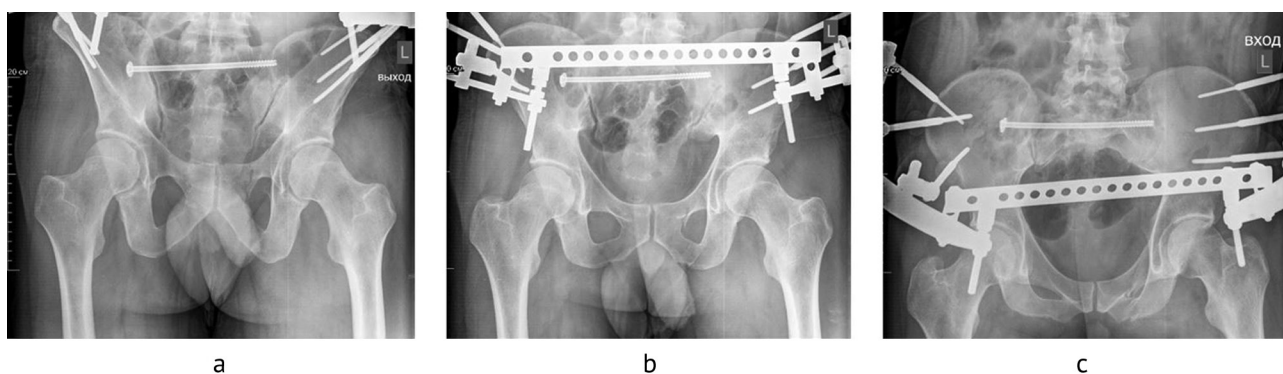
Checking radiographs after surgery: *a* — outlet projection; *b* — overview projection; *c* — inlet projection
